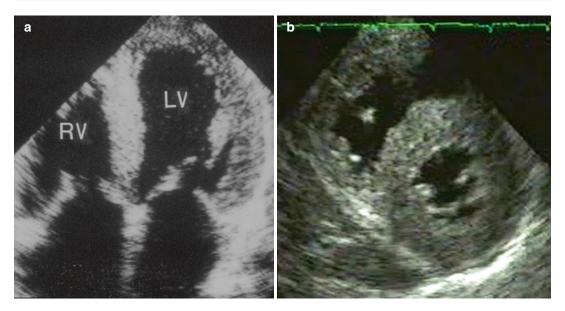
Systemic amyloidosis. Apical four-chamber view (a) and short-axis (b) demonstrating marked wall thickness (15 mm) concentrically. Note the homogeneous
